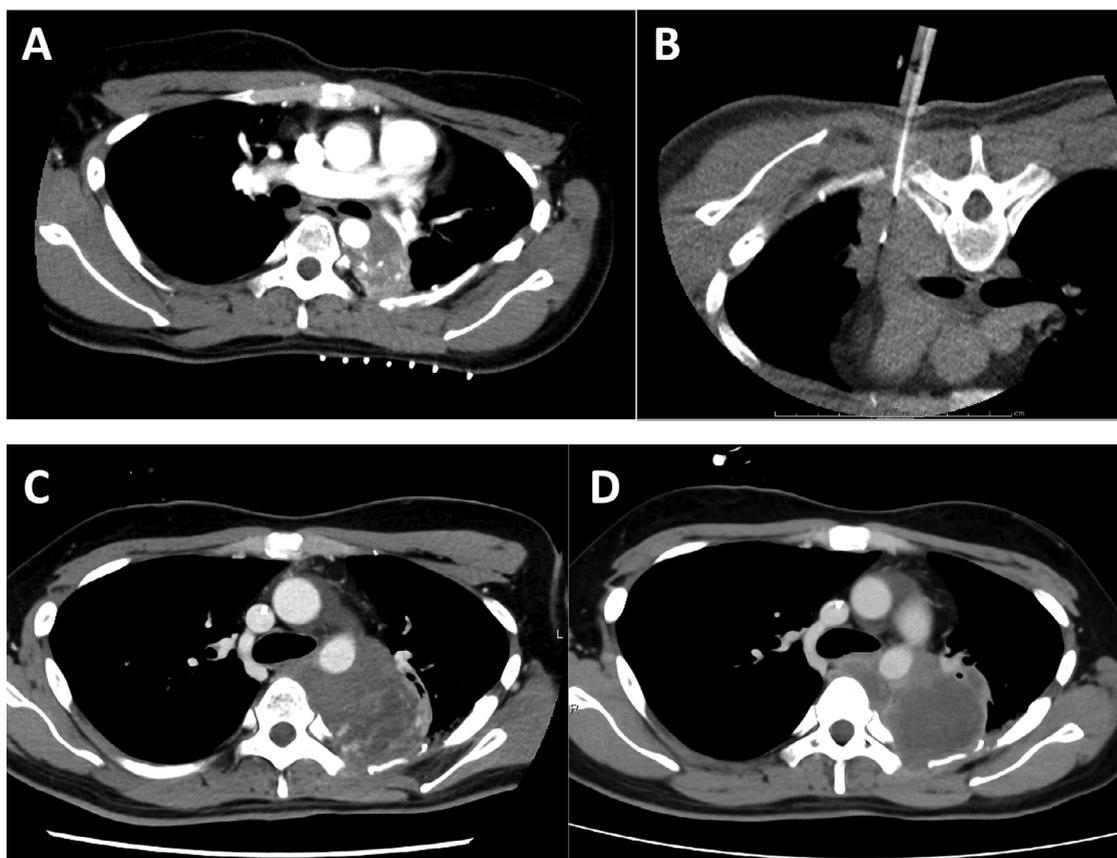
(A) CT scan image of the secondary UPS. (B) CT scan image of fluoroscopic biopsy procedure by interventional radiologists. (C) CT scan image of the secondary UPS at the beginning of ifosfamide, carboplatin, and etoposide therapy. (D) CT scan image of the secondary UPS 6 months after starting ifosfamide, carboplatin, and etoposide therapy. *Abbreviations:* CT = computed tomography; UPS = undifferentiated pleomorphic sarcoma.
